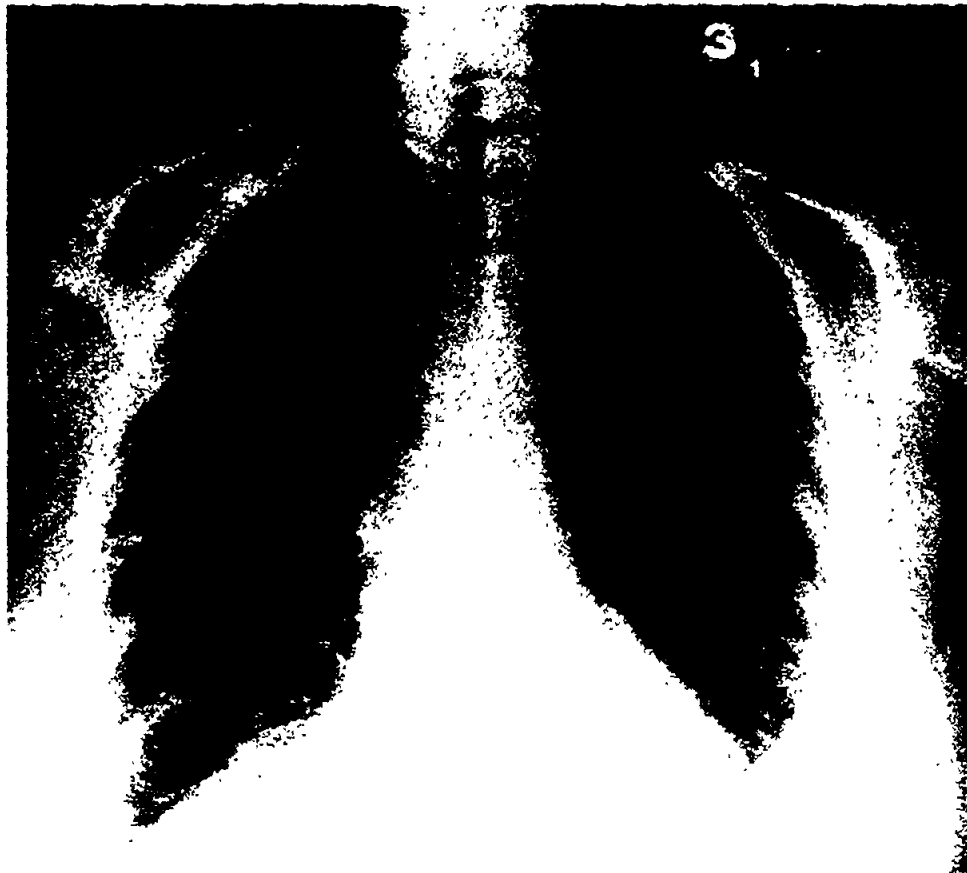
Chest x-ray of patient with a hypersensitivity pneumonitis caused by the inhalation of thermophilic actinomyces contaminating her furnace humidifier
